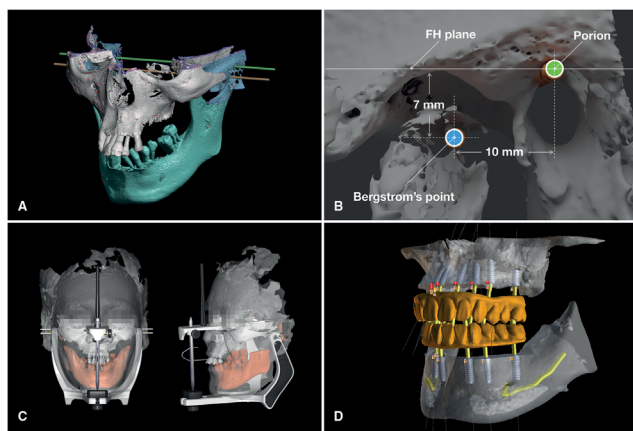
A, CBCT reconstruction with shafts passing through hinge axis and Porion. B, The location of hinge axis (Passing through Bergstrom's point). C, Virtual patient integrated with digital articulator. D, Prosthetic-driven digital implant planning.
